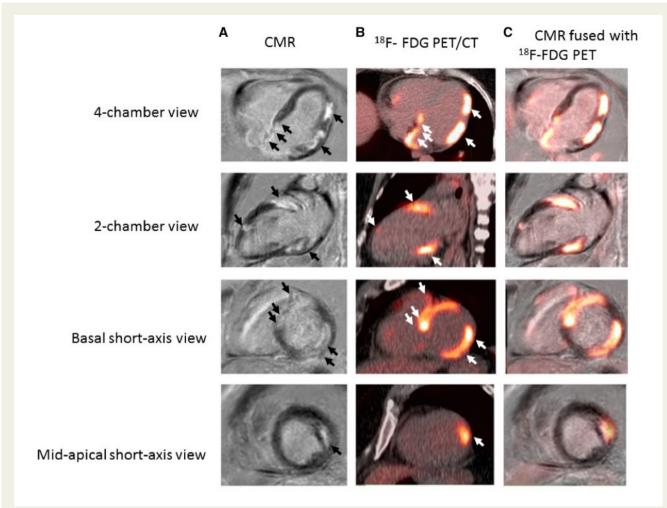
Late gadolinium enhancement-cardiac magnetic resonance (A), 18-F-fluorodeoxyglucose-positron emission tomography-computed tomography (B), and fused cardiac magnetic resonance/positron emission tomography (C). The abnormalities visualized at late gadolinium enhancement-cardiac magnetic resonance (A, arrows) and 18-F-fluorodeoxyglucose-positron emission tomography-computed tomography (B, arrows), show a perfect alignment at fused cardiac magnetic resonance/positron emission tomography, suggestive an acute inflammation rather than end-stage replacement fibrosis.
